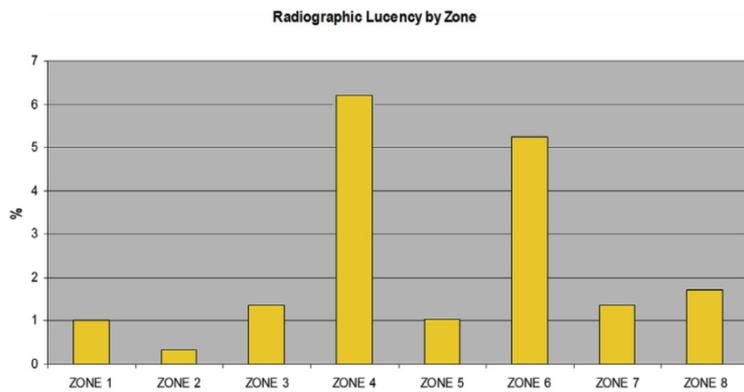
Radiographic lucency evaluated by humeral stem zone.⁵
